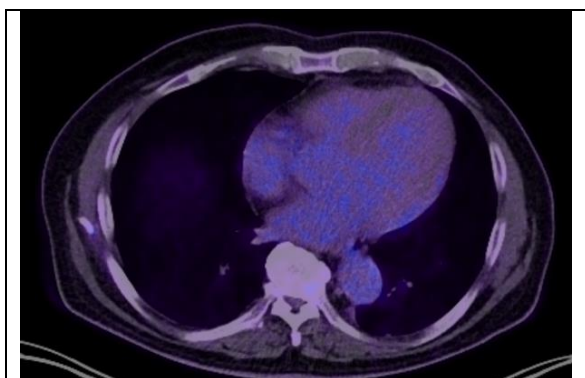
Interim and end-of-treatment positron emission tomography-computed tomography demonstrating marked metabolic response following immunochemotherapy and complete metabolic remission on surveillance imaging (Deauville score 2).
